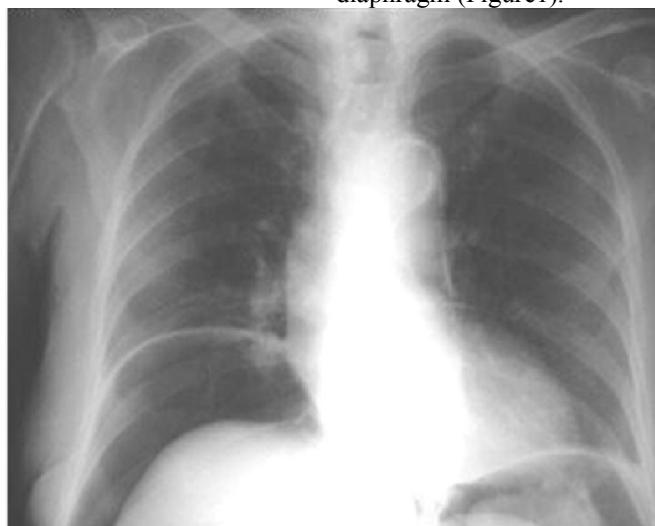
Chest X-ray revealed air under the diaphragm
